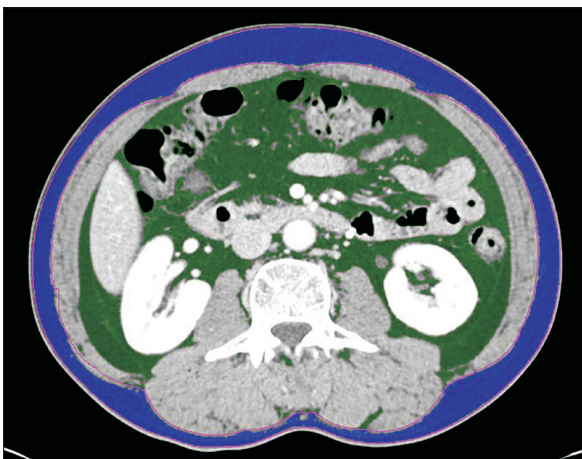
Measurement of the subcutaneous and visceral adiposity. Axial computed tomography obtained at the level of the third lumbar vertebra showing the region colored blue represent the subcutaneous fat area and green represented the visceral fat area.
